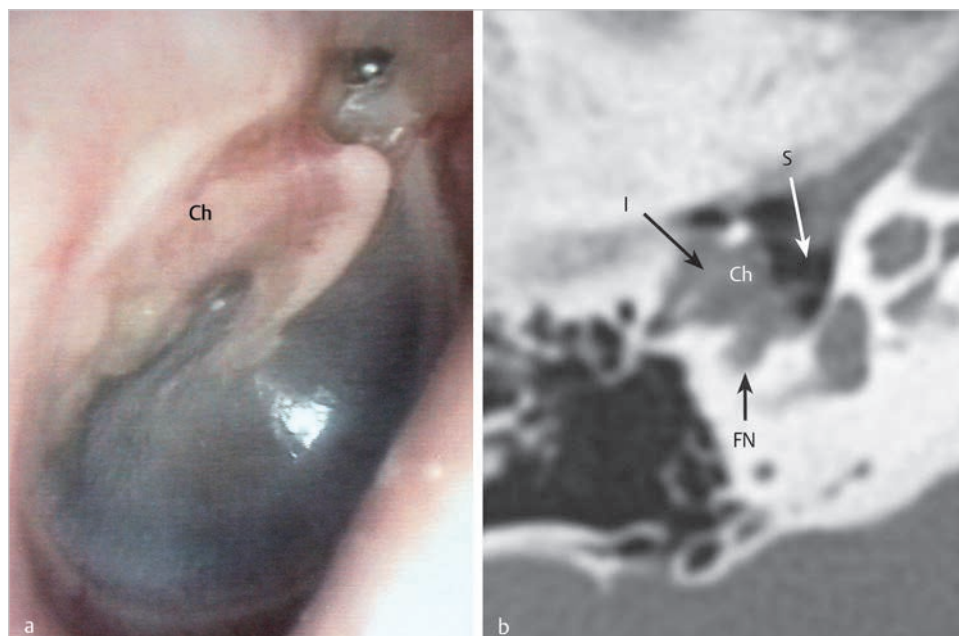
(a, b) A case of small mesotympanic cholesteatoma treated with one-stage canal wall up tympanoplasty. On otoscopy, a cholesteatoma is seen in posterosuperior quadrant. The CT revealed its posterosuperior localization in the tympanic cavity, and absence of pathology in the well-pneumatized mastoid. The long process of the incus is eroded explaining preoperative conductive hearing loss. Ch, cholesteatoma; FN, facial nerve; I, incus; S, stapes.
